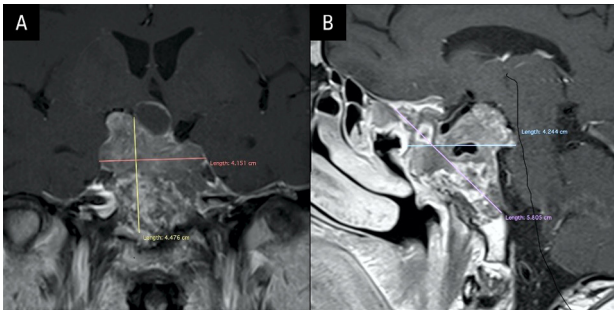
Magnetic resonance imaging (MRI) before temozolomide treatment — 24.06.2021. A. Cranio-caudal (CC) plane; B. Sagittal (Sag) plane
